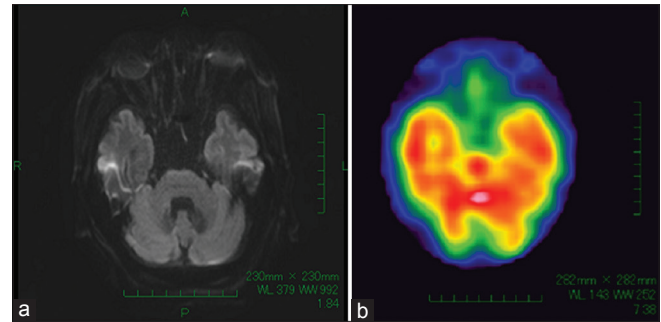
(a) The axial diffusion-weighted magnetic resonance imaging scan revealed no ischemic region. (b) On the single photon emission computed tomography image, there is no evidence of a decrease in cerebral perfusion in the posterior circulation
